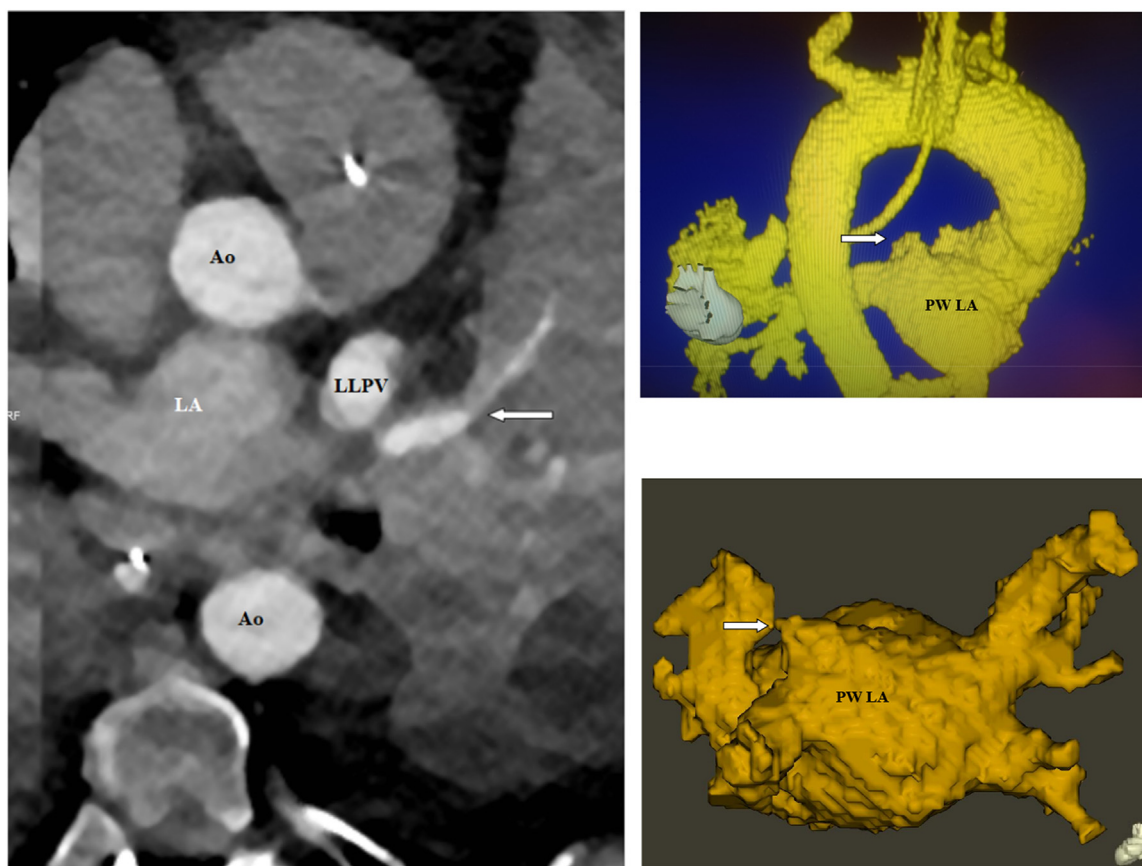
(A) Contrast-enhanced computed tomography scan with pulmonary artery catheterization showing upper left pulmonary vein stenosis (arrow). Ao, aorta; LA, left atrium; LLPV, left lower pulmonary vein. (B) 3-dimensional reconstruction of the posterior wall of the left atrium (PW LA) showing absence of the left upper pulmonary vein (arrow).
